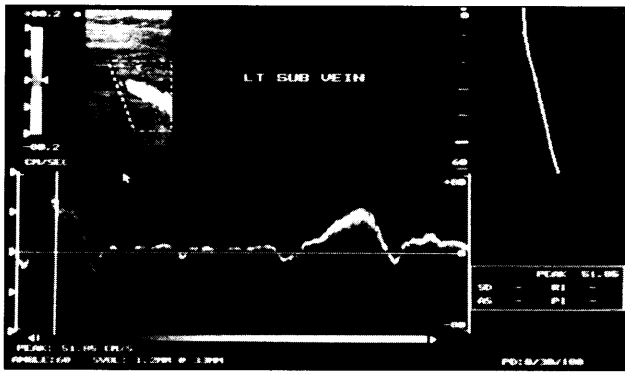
Doppler ultrasound showing patency and pulsatile waveform indicating good flow and no obstruction in the left subclavian vein
